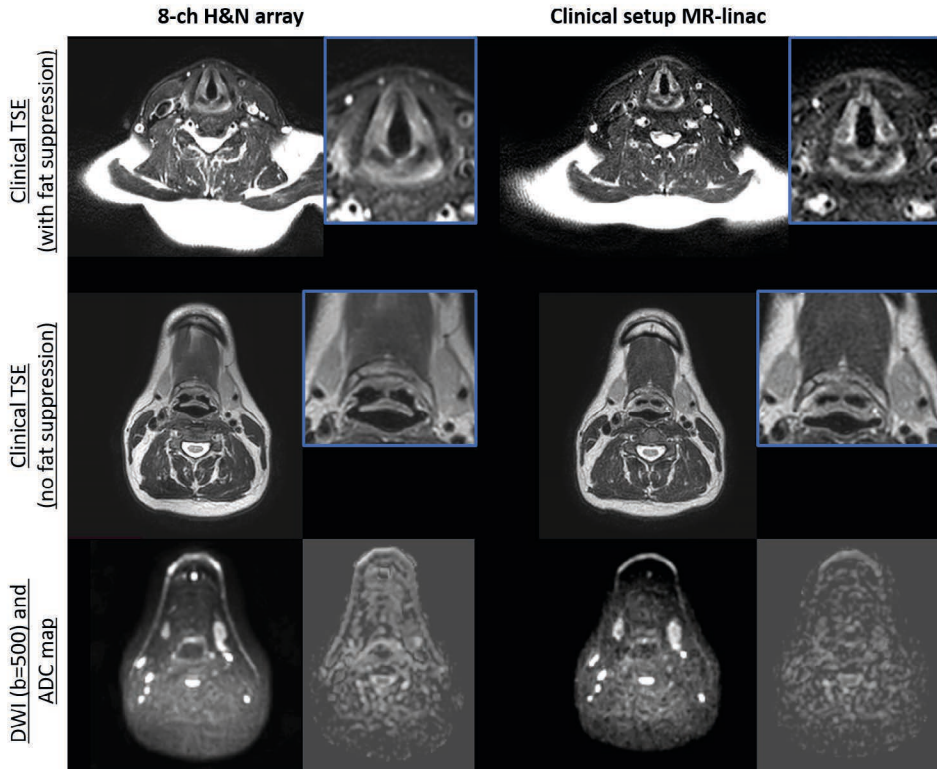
In-vivo images for three acquisitions with the 8-channel H&N array (left) and 8-channel clinical MR-linac array (right). The three sequences consisted of a TSE with fat suppression, a TSE without fat suppression, and a DWI sequence. For the latter, the $b=500$ image is shown and the calculated ADC map of that slice.
